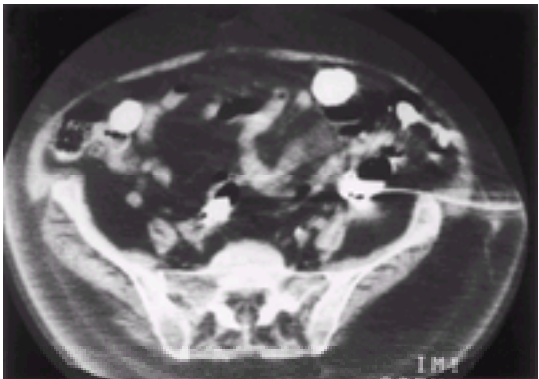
CT scan showing percutaneous drainage of pelvic abscess.
